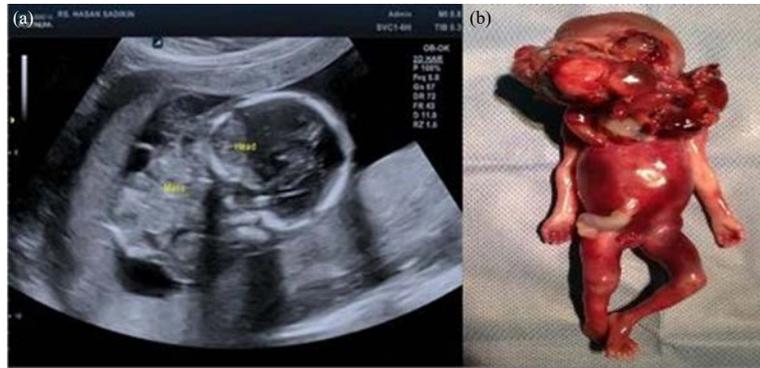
(a-b): Irregular mass in area fetal face, (a) Ultrasound examination and (b) Postnatal
